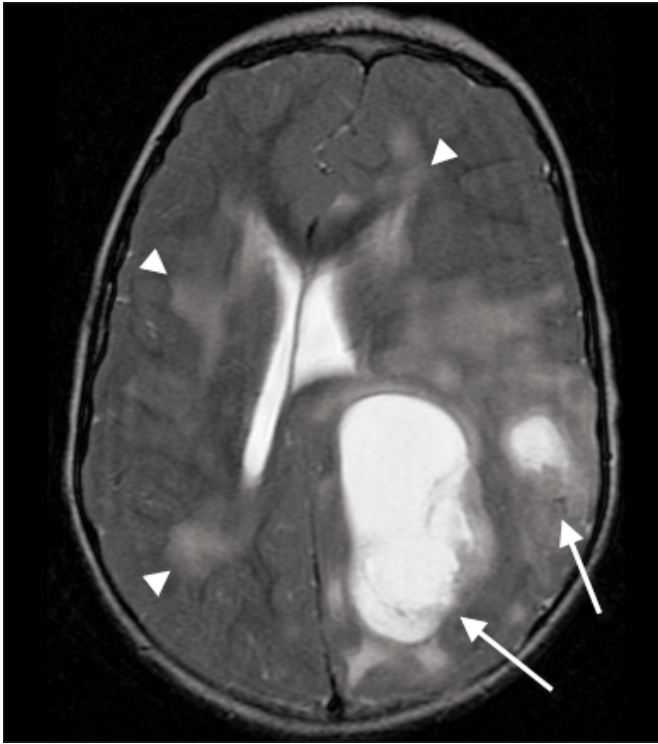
Patient 2: Axial T2-weighted MRI at level of lateral ventricles showing multifocal PNET (arrows) and white matter injury from previous chemotherapy and radiotherapy (arrowheads).
